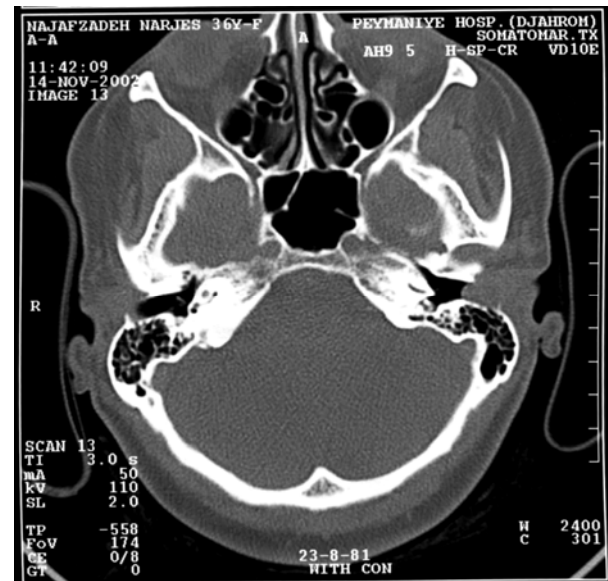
CT scan. A soft tissue mass in the EAC with obliteration of the canal.
